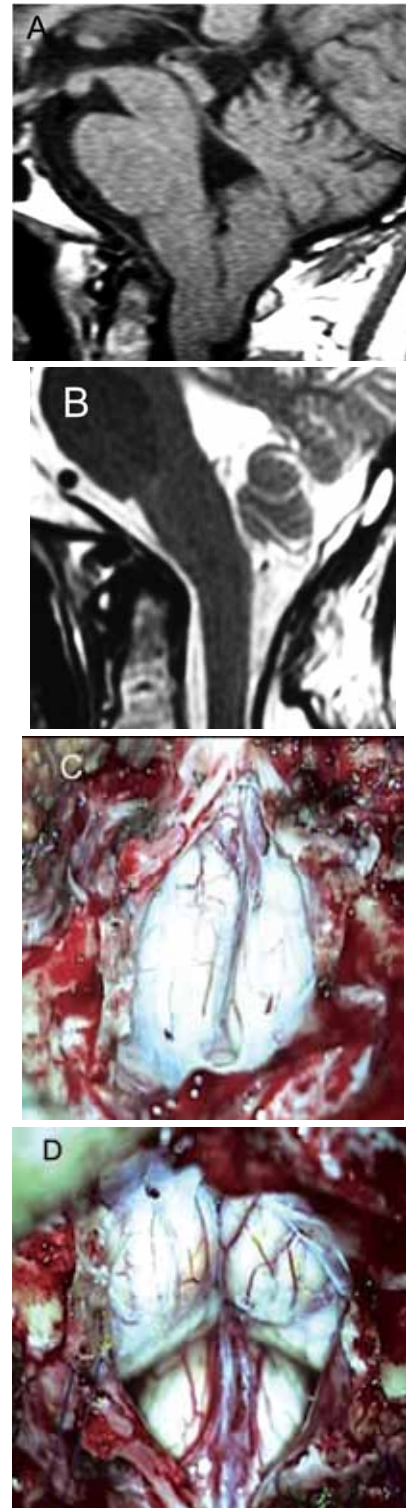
(A) Preoperative sagittal T1 MR imaging demonstrating cerebellar tonsil herniation through the FM. (B) Postoperative sagittal T2 imaging after FM decompression and partial reduction of cerebellar tonsils, showing the CSF around brainstem and cerebellum, indicating that adequate decompression was achieved. (C) Operative image of the same patient demonstrating herniation of both cerebellar tonsils through the FM. (D) Operative image after partial subpial aspiration of cerebellar tonsils and lyses of adhesion, revealing reduction of the tonsils size and the spinal medullary junction.
